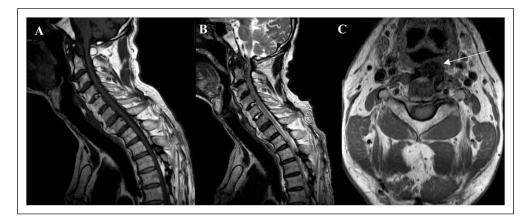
(A) MRI TI-weighted sagittal image (2014) of the patient's cervical spine showing C2-C7 syndesmophytes. (B) MRI T2weighted sagittal image (2020) of the patient's cervical spine. (C) MRI TI-weighted axial image (2014) of the cervical spine at the C2-C3 level showing C2-C3 syndesmophytes compressing the hypopharynx (arrow). MRI: magnetic resonance imaging.
